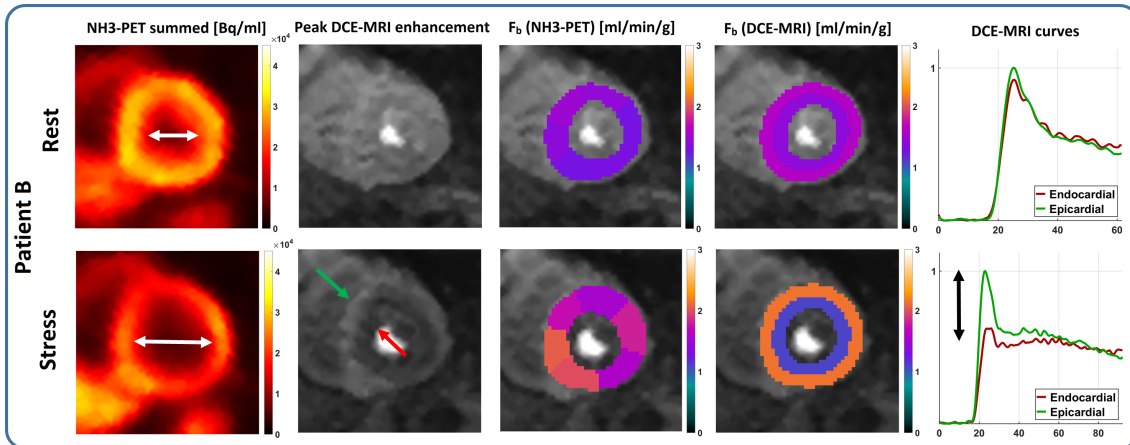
Clinical example case for combination of PET and DCE-MRI in a patient with stable angina, significant left-ventricular hypertrophy, but without any high-grade stenosis in either RCA or LAD at the time of the scan. PET data suggested classification as a case of apparent left-ventricular cavity dilatation (LVCD), however lacking a true morphologic reference with respect to the dilatation. The latter is provided from simultaneously acquired MRI data, where DCE-MRI revealed strong endo- to epicardial perfusion gradients at stress concordant with microvascular disease and disproving an actual cavity dilatation.
